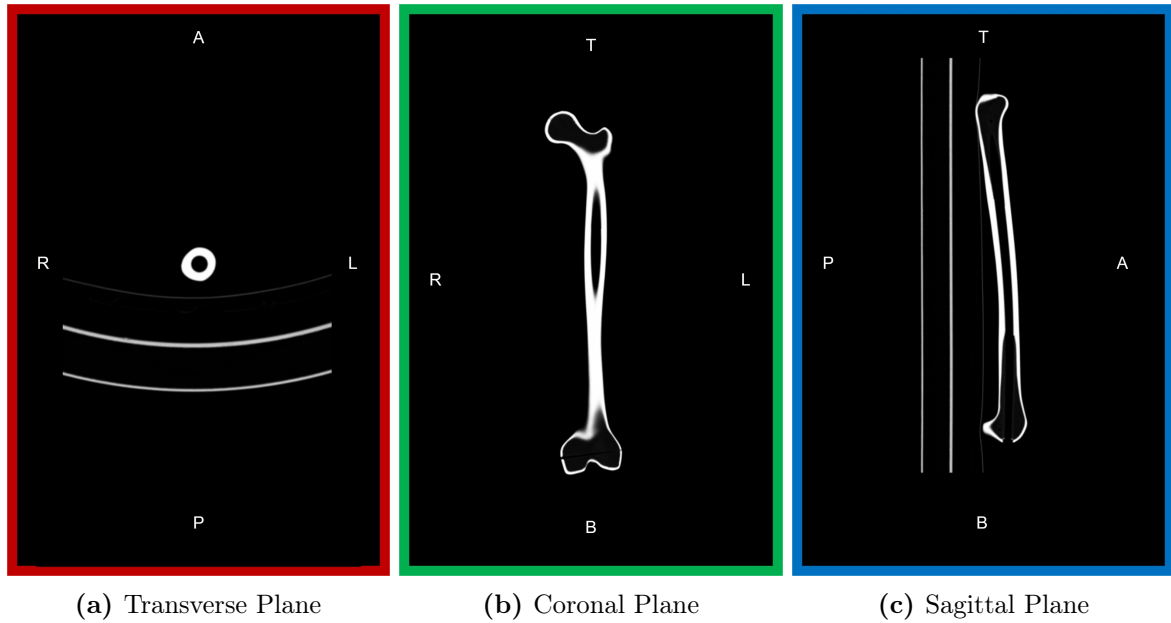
CT Scan Images of the Femur
